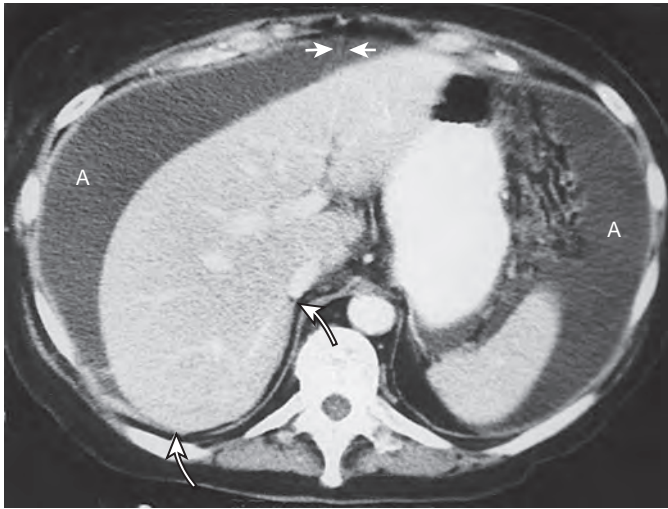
Falciform ligament and bare area of liver. CT of the upper abdomen shows a large amount of ascites (A) outlining the falciform ligament (*straight arrows*). Along the posterior aspect of the right lobe, there is a region not surrounded by the fluid: the bare area (*curved arrows*). This represents the portion of the liver that developed in contact with the septum transversum and that is not covered by the peritoneum.
